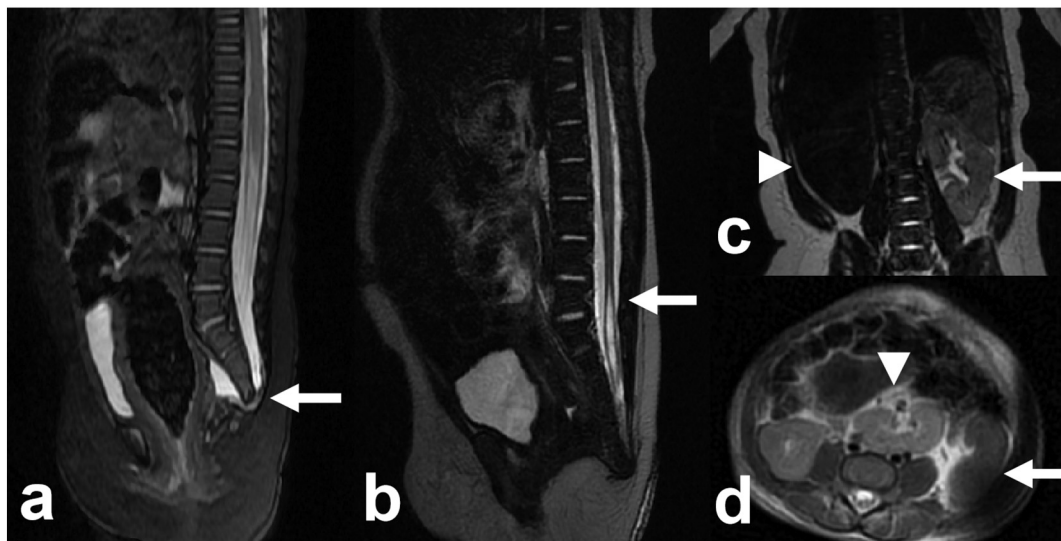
Associated malformations in T2WI MR images. a. Anterior meningoceles (white arrow). b. Tethered spinal cord (white arrow). c. Isolated kidney (white arrow): the right kidney was absent (white arrow head) d. Ectopic kidney (white arrow head): the location of left kidney was replaced by intestinal canal (white arrow).
